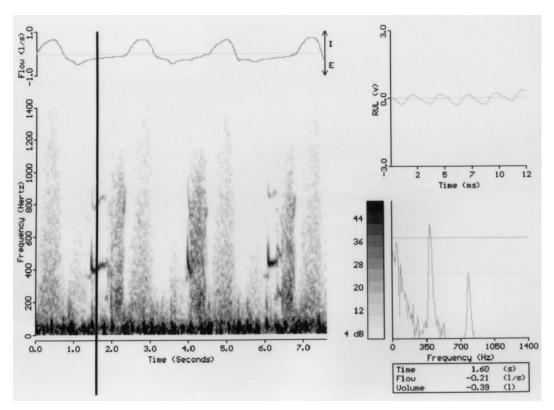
Digital respirosonogram of sounds over the right anterior upper lobe during three complete respiratory cycles in a boy with asthma. Time is on the horizontal and frequency on the vertical axis. Sound intensity (in decibels) is shown on a gray scale. Airflow is plotted above the sonogram. The vertical bar at 1.6 s highlights a segment of expiratory sound that contains wheeze. This segment is shown in detail on the right, revealing a sinusoidal wave in the time-amplitude display (top) and two harmonically related peaks in the Fourier power spectrum (bottom).
